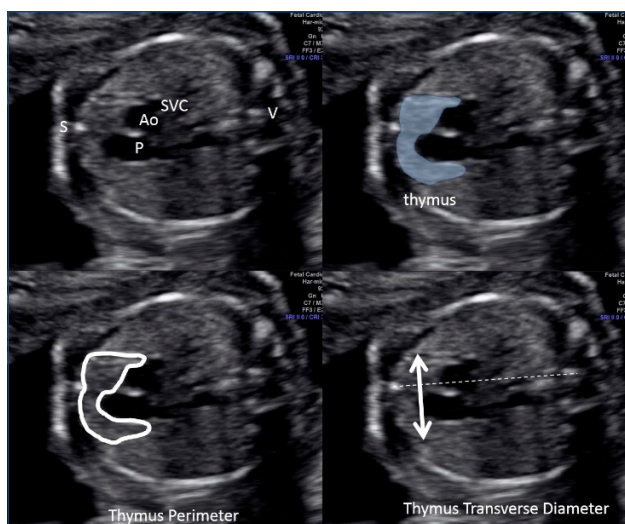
Sonographic fetal thymus measurement. S: sternum; P: pulmonary artery; Ao: aorta artery; SVC: superior vena cava; V: vertebra.
